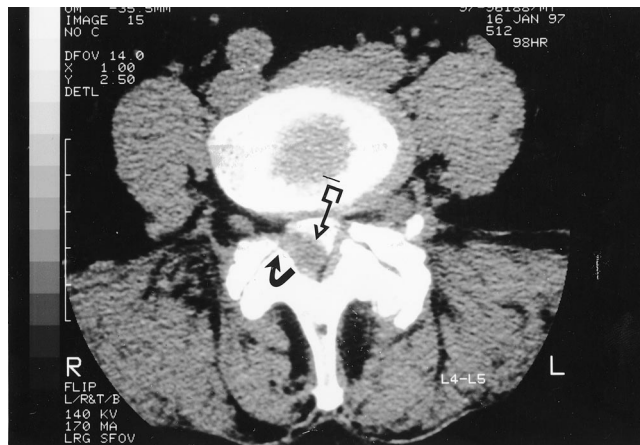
A transaxial myelo-CT study at L4–L5 reveals a right-sided extradural lesion originating from the facet joint (curved arrow) in a patient who also demonstrated Grade 1 olisthy. This extradural synovial cyst herniation contributed to marked thecal sac (straight arrow) and right L5 root compression.
